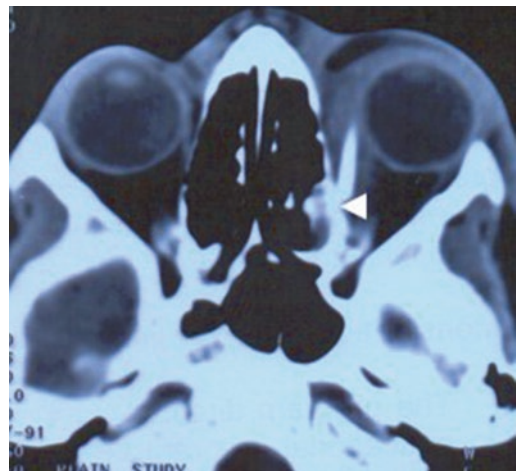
Axial CT of a 7 years old child revealed presence of an elongated hyper-dense foreign body penetrating the medial rectus muscle and embedded in the left medial orbital wall (arrow) surrounded by soft tissue density in keeping small hemorrhage
